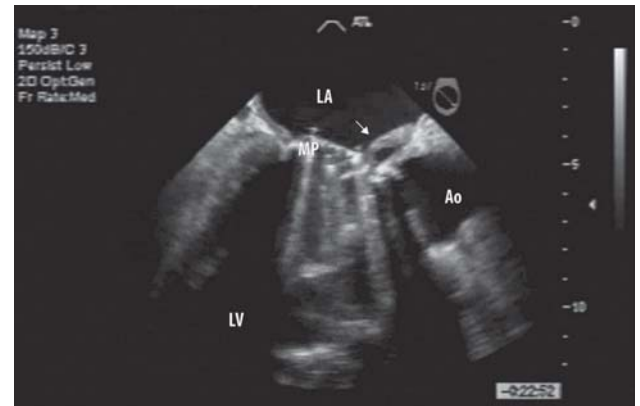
Transesophageal long-axis view showing a small abscess at the mitral-aortic intervalvular fibrosa. Abscess is the abnormal echolucent area within the intervalvular fibrosa
